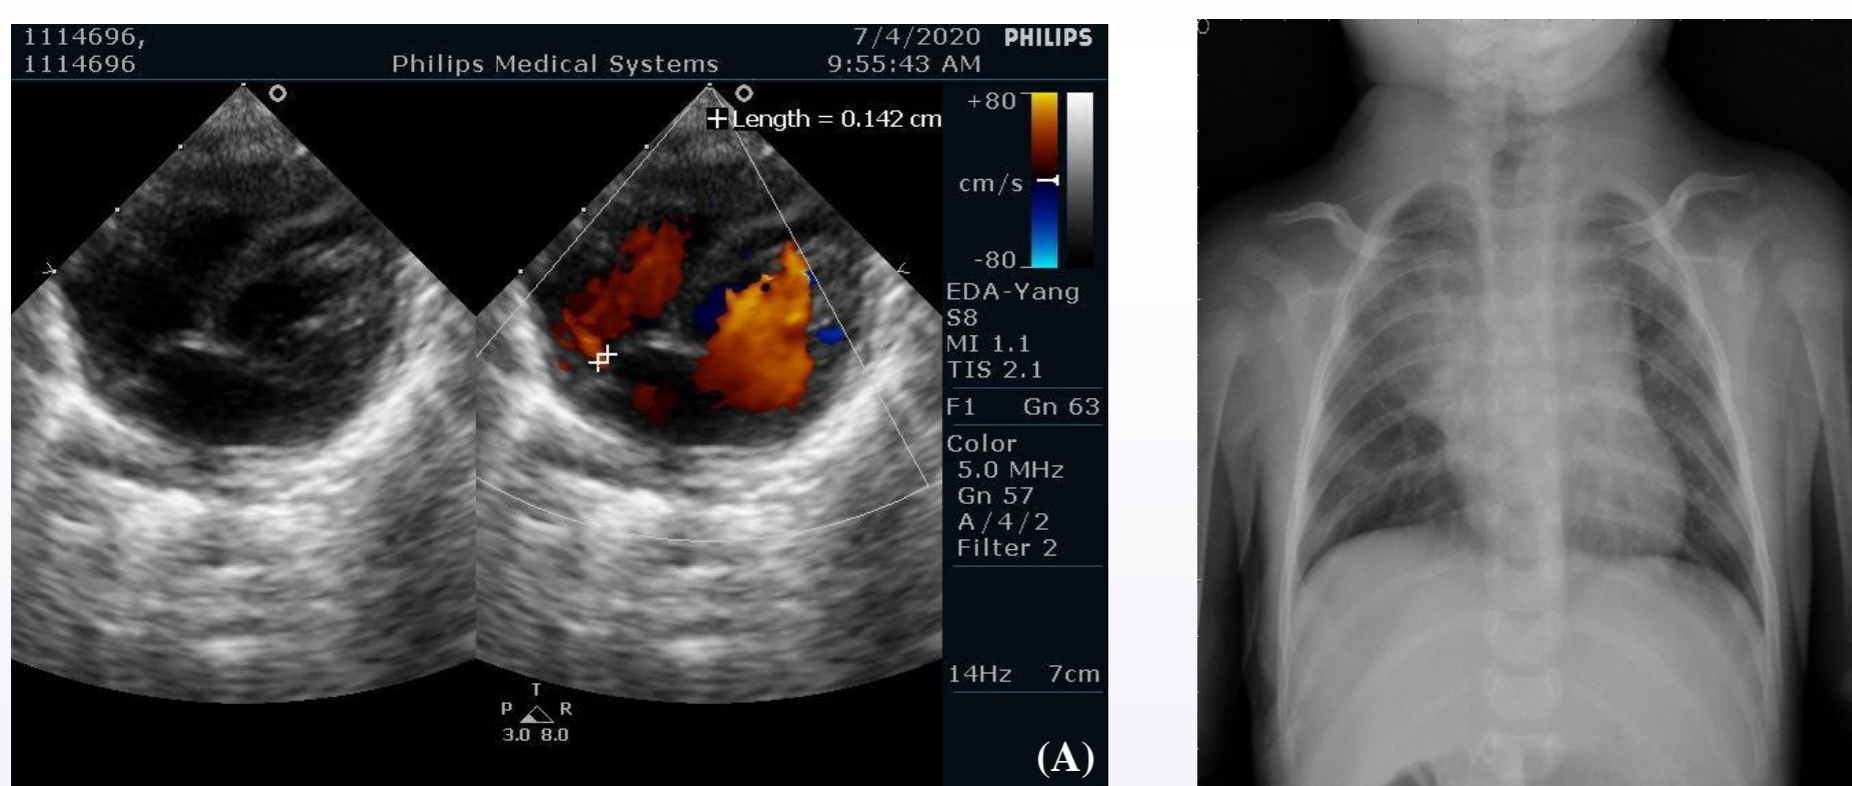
· The diagnosis of doppler color flow mapping in sonography (A).The chest x-ray (B). Suspect secundum type atrial septal defect.
